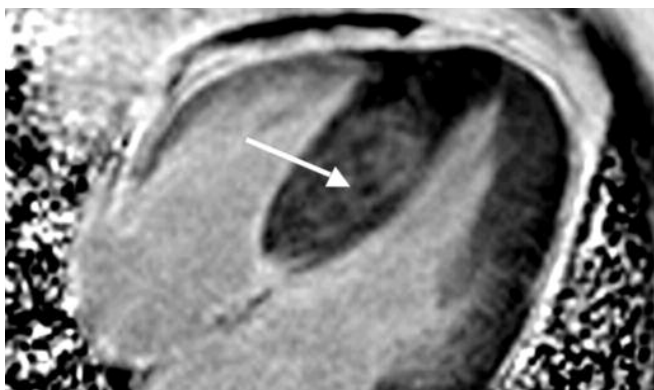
Cardiac MRI demonstrating again marked septal hypertrophy (white arrow) with later gadolinium enhancement (patchy white areas within the septum) in keeping with extensive fibrosis
